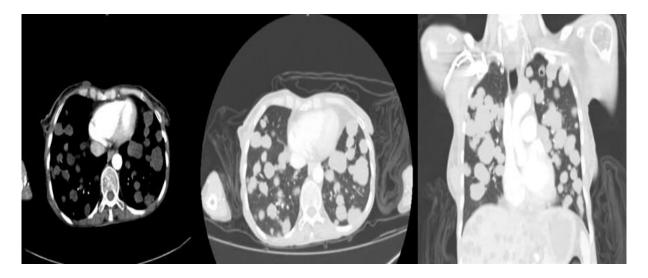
Axial and coronal reconstruction view of contrast-enhanced CT scan show multiple cystic lesions in lungs
